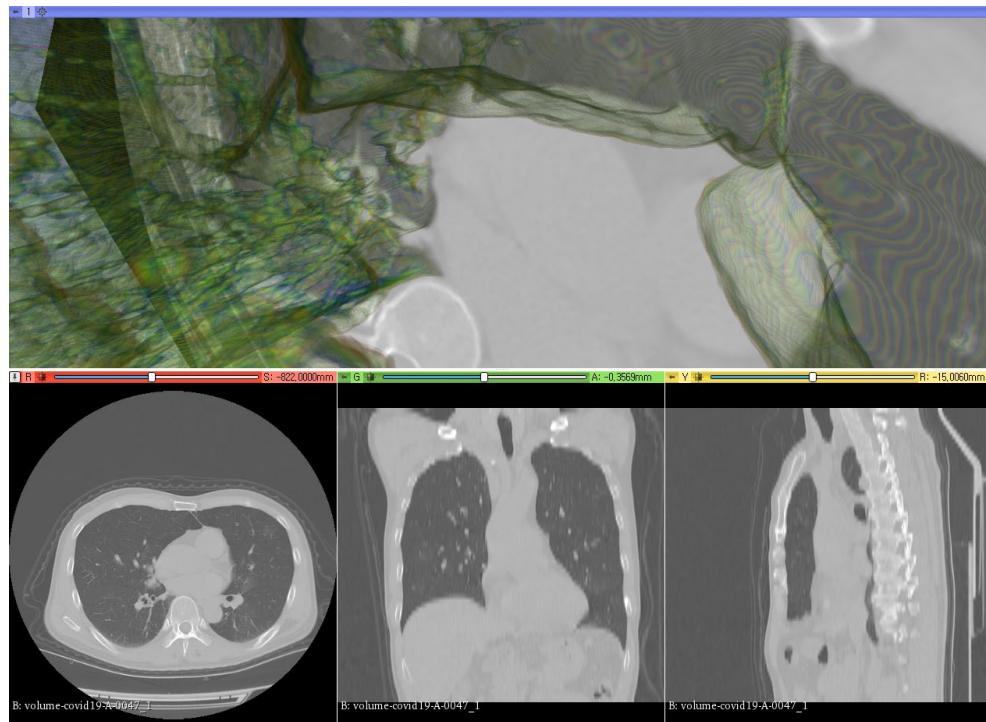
COVID Patient 347 Lung CT Scan: 2D and 3D Rendering Using 3D Slicer
